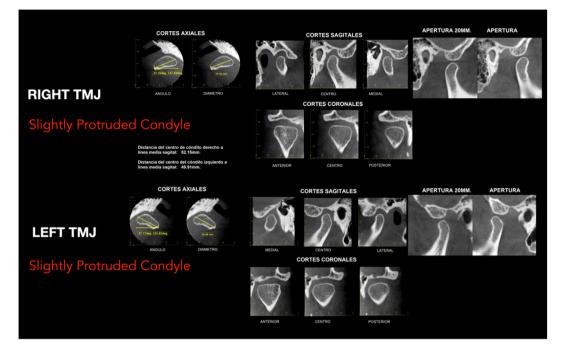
Initial CBCT of the temporomandibular joints.
